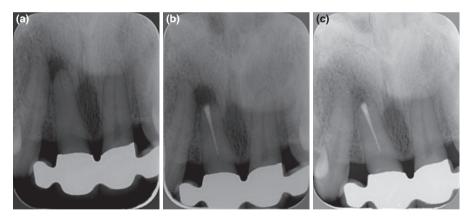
(a) A 32-year-old woman with aplasia of the maxillary lateral incisors. Pulp necrosis and apical periodontitis were diagnosed in the right central incisor. (b) Immediate postoperative radiograph. (c) The 1.5-year follow-up shows a resolution of the periapical radiolucency.
